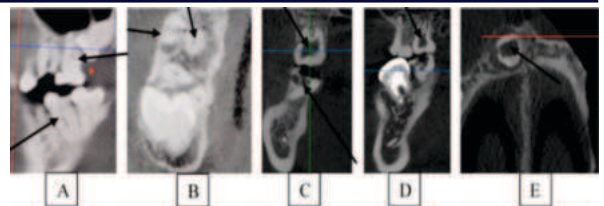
CBCT sections (transaxial and axial) shows DI (A and B), DD (C and D) and Regional odontodysplasia (E)
